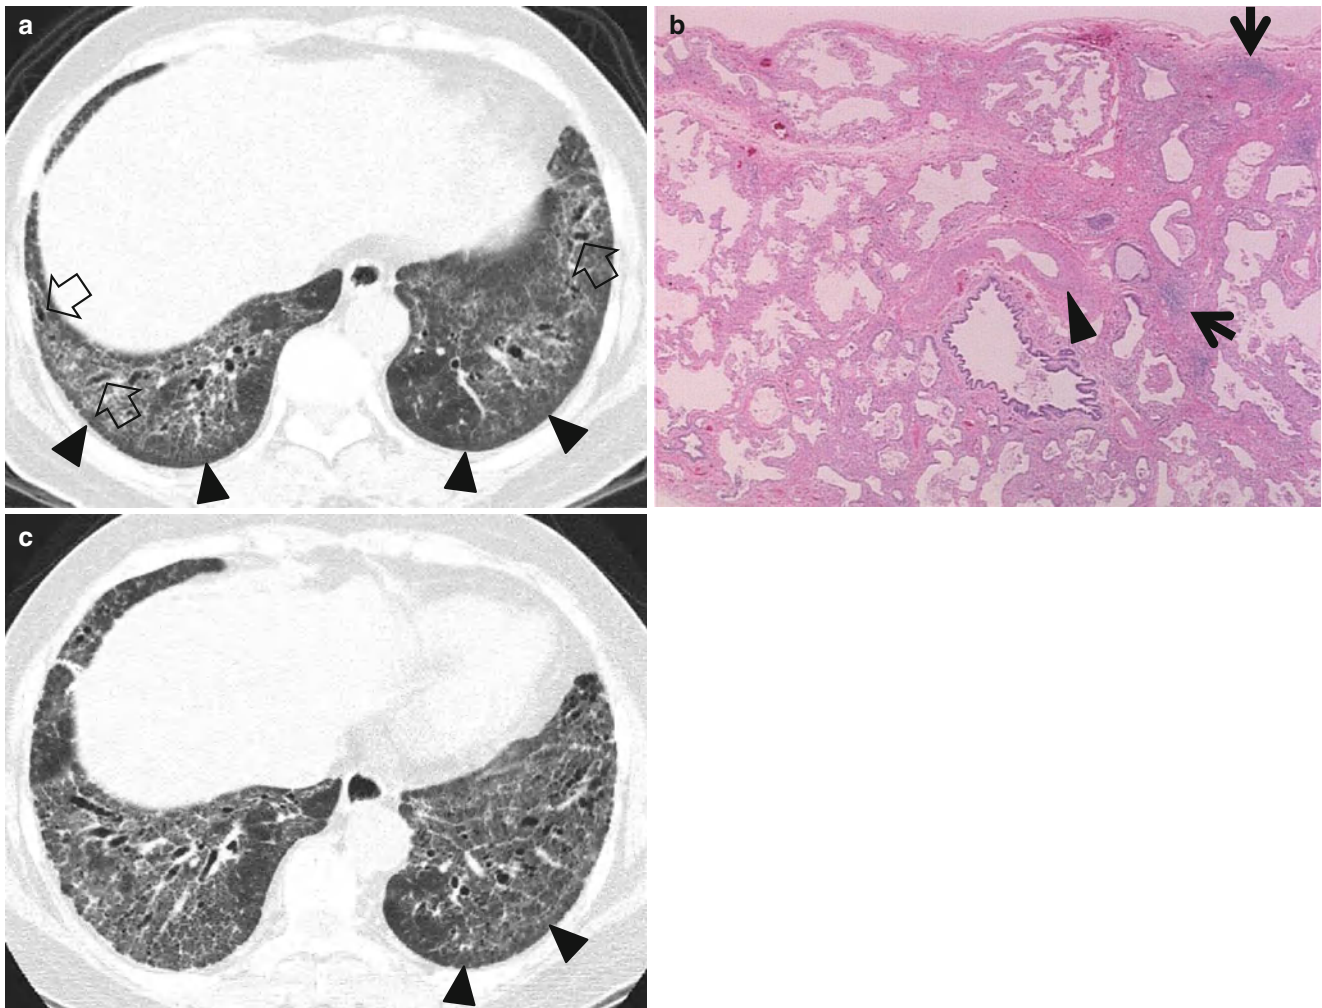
Fibrotic nonspecific interstitial pneumonia in a 50-year-old woman. (a) Lung window image of thin-section (1.0-mm section thickness) CT scan obtained at level of liver dome shows patchy areas of reticulation and ground-glass opacity in bilateral lower lung zones. Subpleural sparing (*arrowheads*), one of important signs that help differentiate usual interstitial pneumonia from this disease on CT, is clearly seen. Also note traction bronchiectasis (*open arrows*). (b) Low-magnification ($\times 40$)
